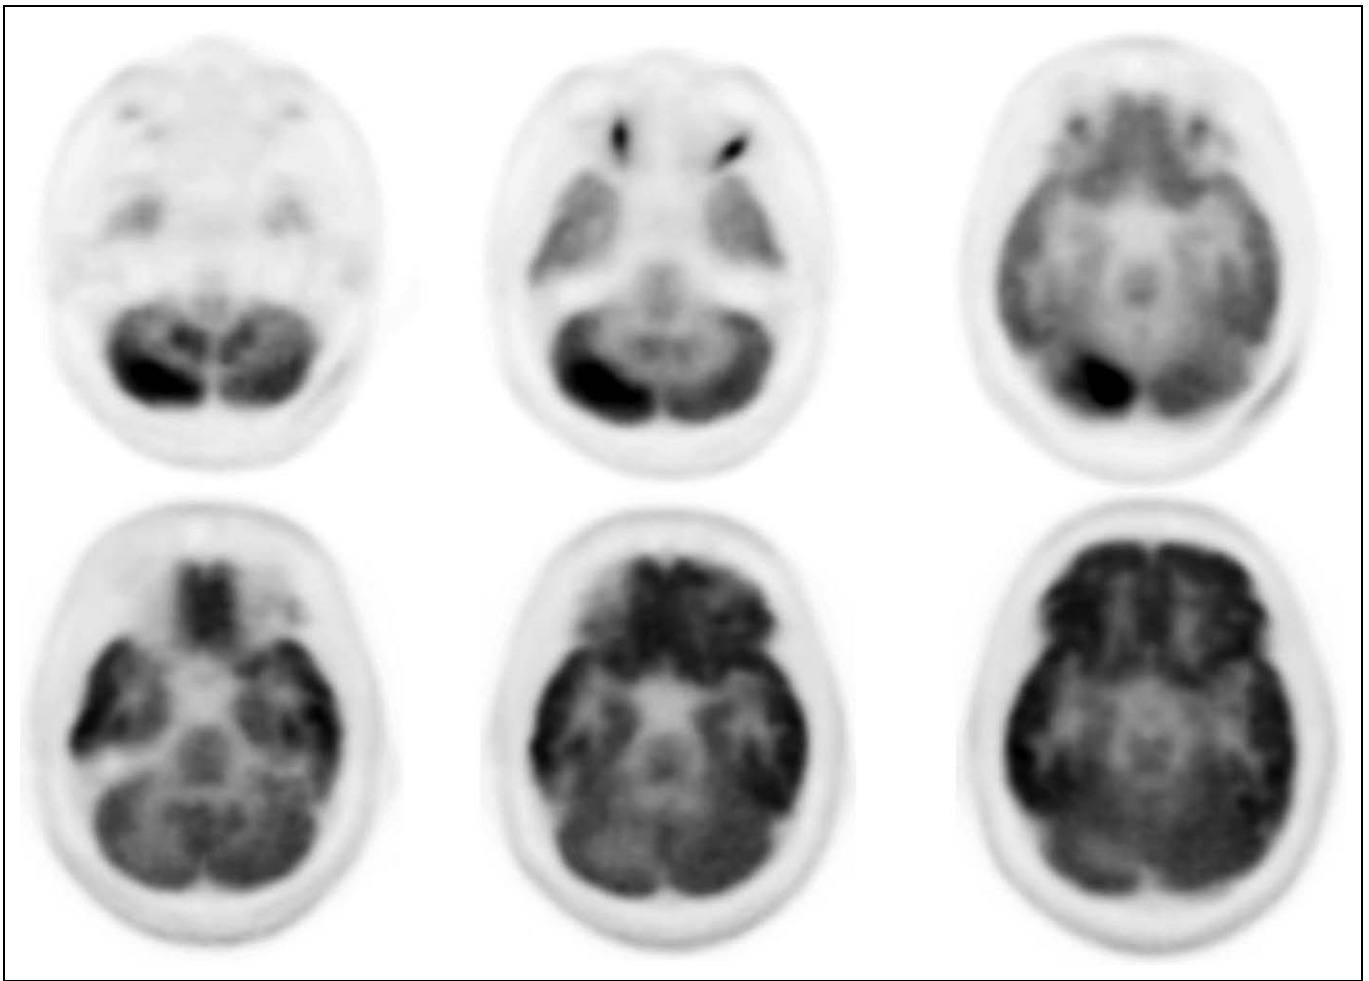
FDG-PET scan. Top row: focal intense hyper-metabolism in right cerebellar cortex and diffuse hypo-metabolism of bilateral cerebral hemispheres. Bottom row: focal hypo-metabolism in the right cerebellar cortex, corresponding with the initially hyper-metabolic region.
